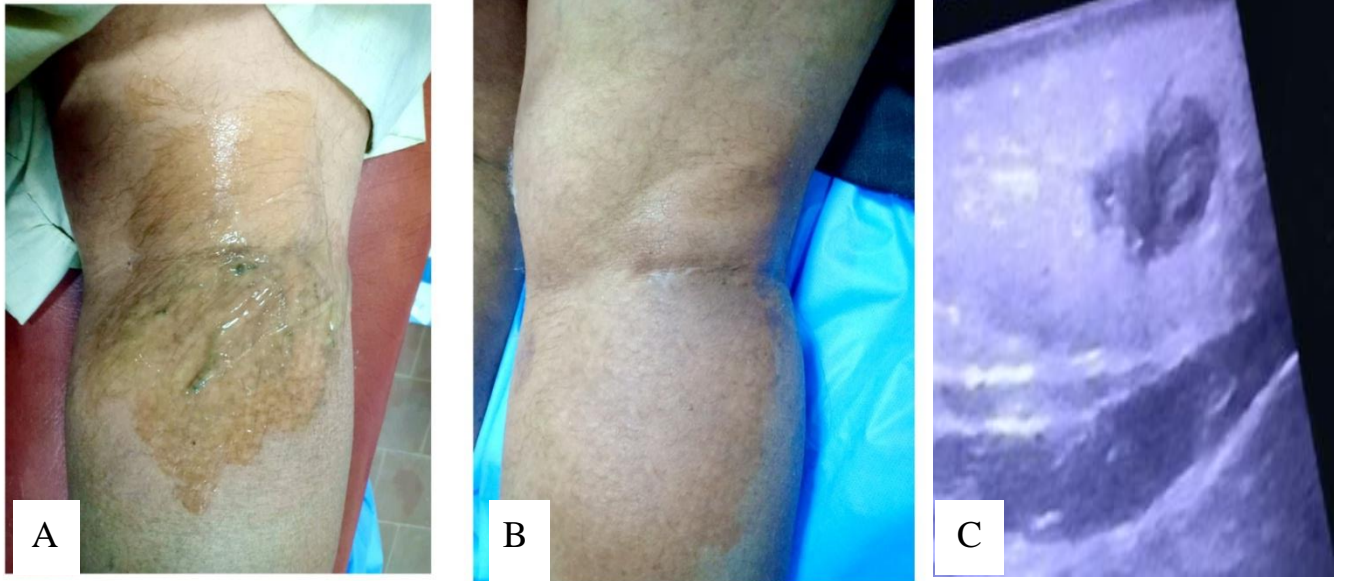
Case no. 4: (A) *subcutaneous varicosities at posterior aspect of upper leg.* (B) *After one session of UGFS, total disappearance of varicosities.* (C) *Ultrasound examination, the treated vein totally thrombosed with fibrosis changes.*
